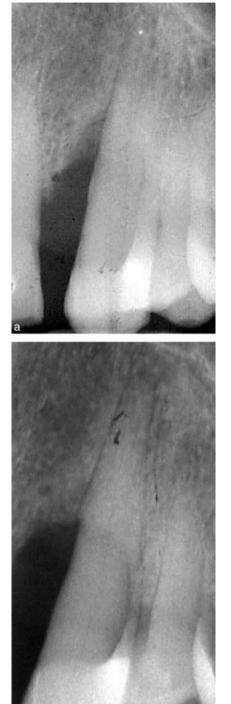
Pre-surgical (a) and 6 months –postsurgery (b) radiographic aspect of the intraosseous defect.
